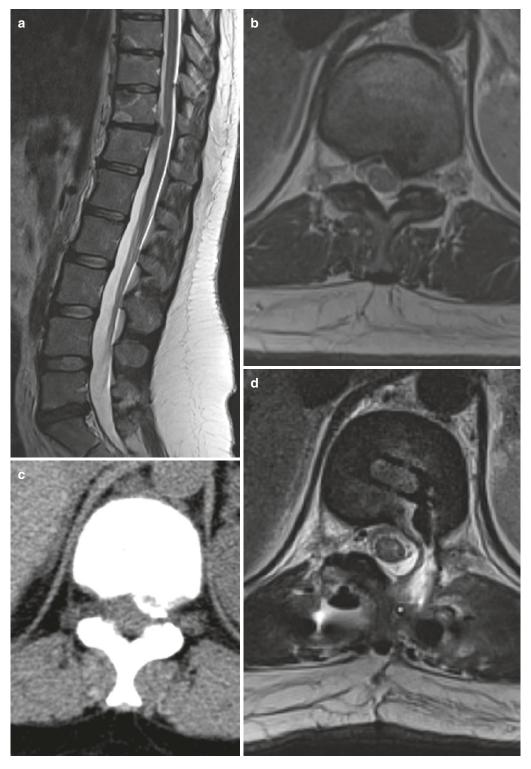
Preoperative sagittal MR image (a), axial MR image (b), and CT scan (c) demonstrating hard disc extrusion compressing spinal cord on T11–12 level. After TTIF
